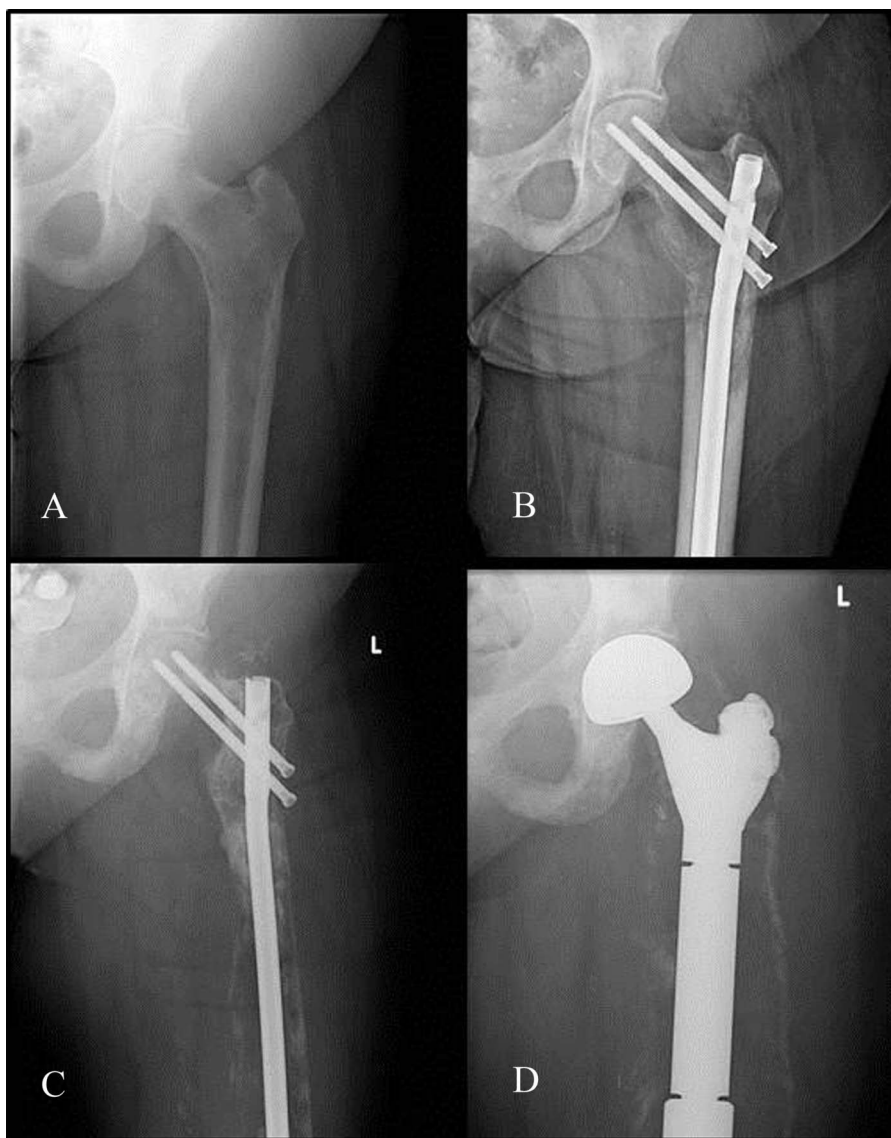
A-D A 62-year-old woman with metastatic ductal carcinoma of the breast presented with an impending pathologic fracture of the left proximal femur 11 years after modified radical mastectomy and chemotherapy. (A) Preoperative radiograph shows a moth-eaten appearance of the bone. (B) Six months after nailing, the bone is still intact. (C) Thirteen months after surgery, there is progression of disease and marked loss of bone. (D) Revision of the implant to a total femoral prosthesis was performed.
